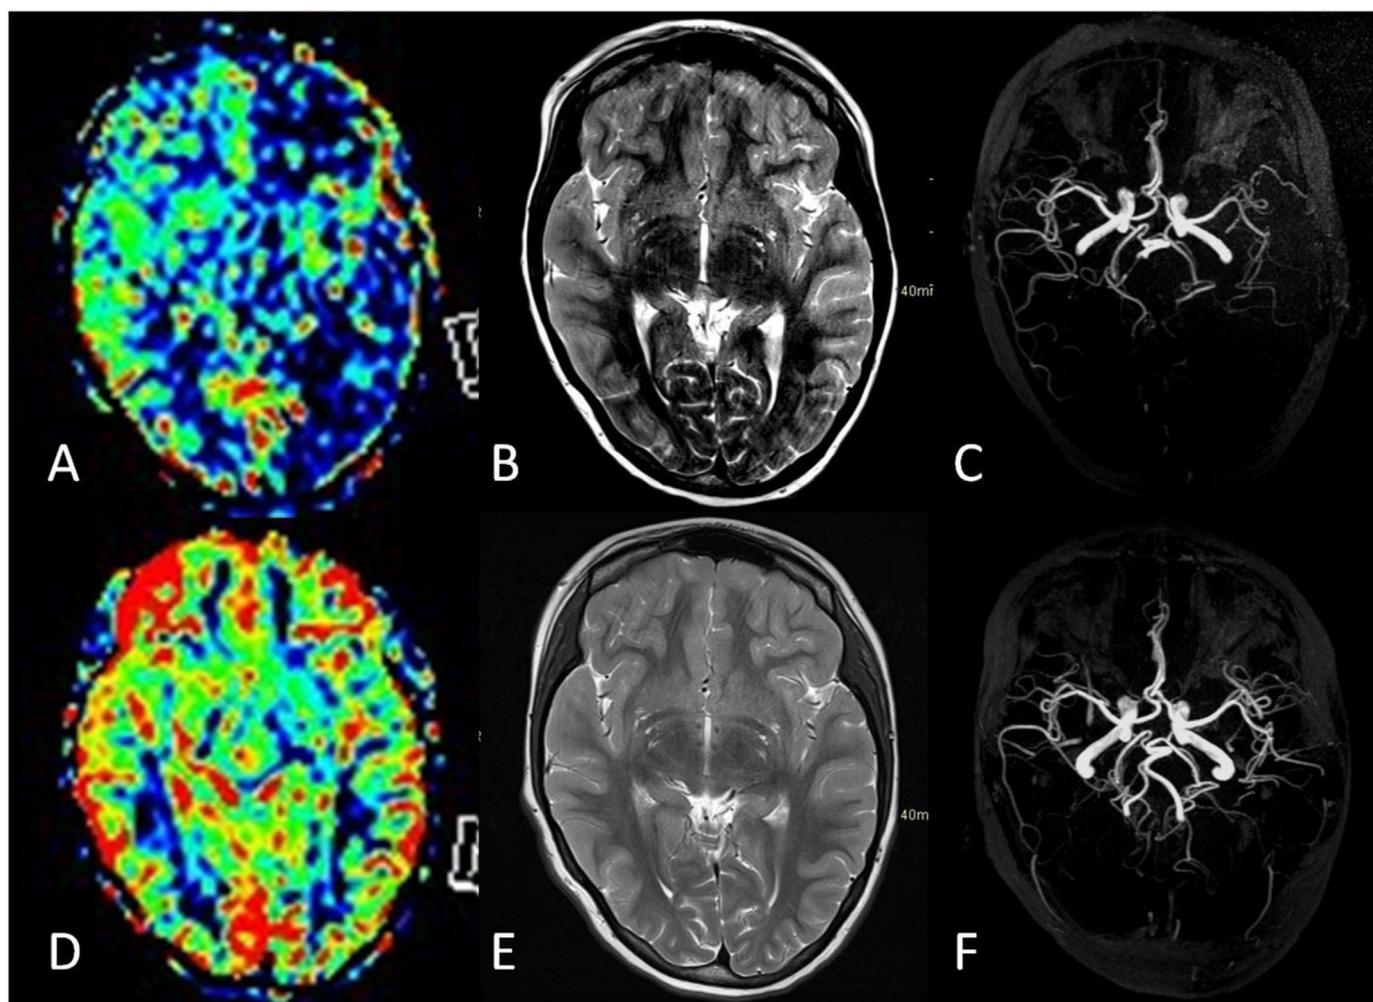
Axial T2-weighted images (A, D), pseudocontinuous arterial spin labeling (B, E) images at the level of the subthalami, and 3D-time-of-flight (C, F) images acquired during symptoms (top row) and after four days (bottom row) show no evidence of parenchymal lesions associated with left hemisphere hypoperfusion and asymmetric representation of the distal middle cerebral artery branches, less evident on the left side in the first examination and no longer evident at subsequent follow-up examination. The color version of this figure is available in the online edition.
